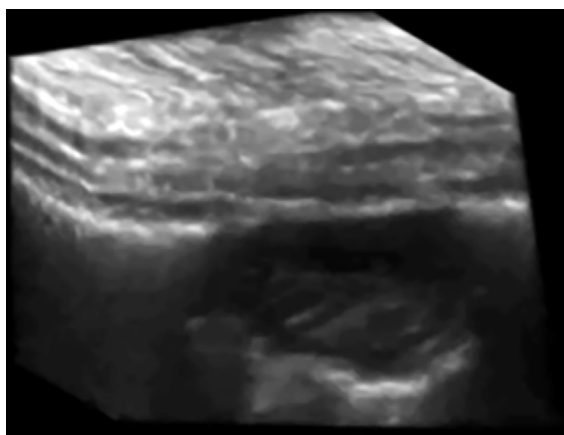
3-D ultrasonographic image of peripheral lung nodule obtained with a Philips CX-50 and 12-3mHz linear transducer. Image reproduced with the patient's permission.
